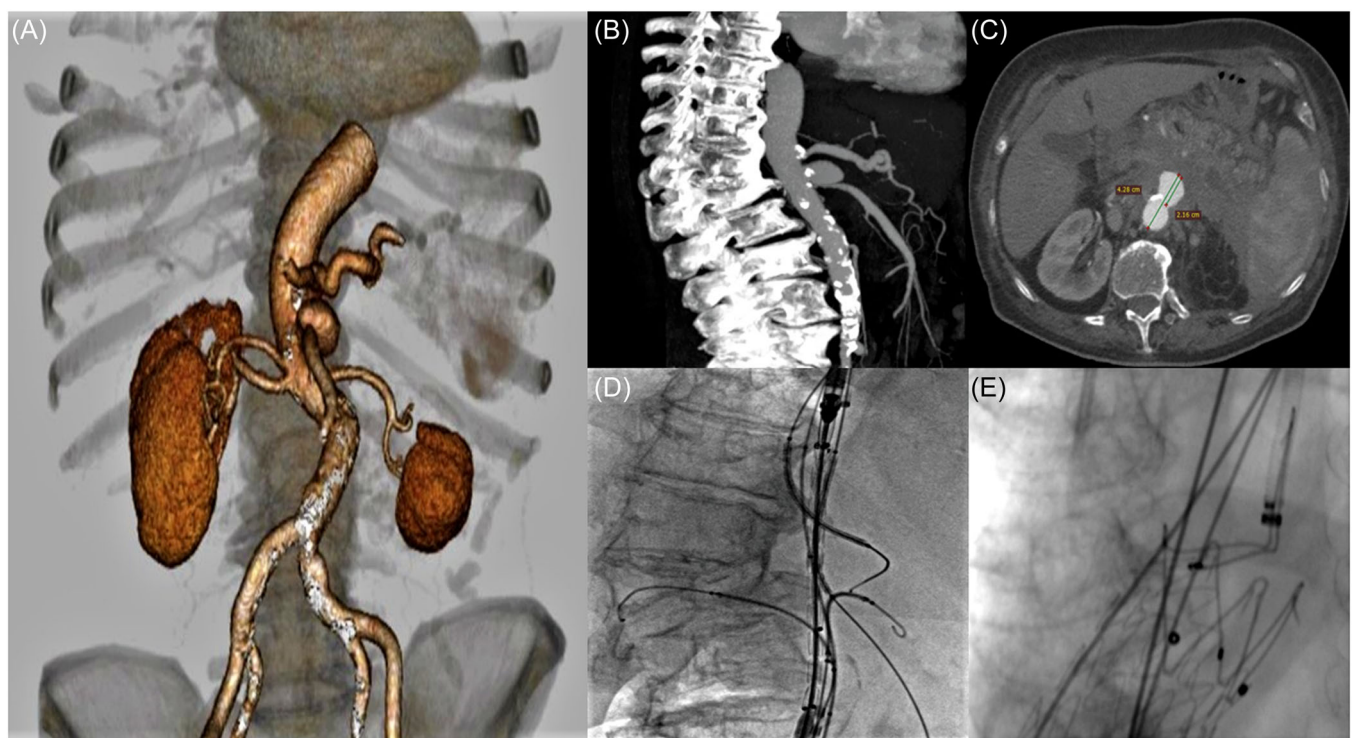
(A) Volume rendering (VR) reconstruction. (B) Large-neck aortic pseudoaneurysm at maximum intensity projection (MIP) computed tomography-scan reconstruction. (C) Anatomical characteristics. (D) Pre-deployment intraoperative phase. (E) Left brachial sheath entrapped into the barbs of the aortouniliac stent-graft. [Color figure can be viewed at wileyonlinelibrary.com]
